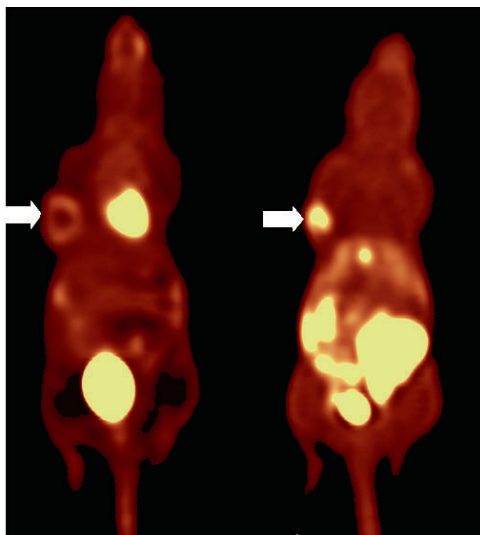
An example of an FDG PET scan showing a tumor with the highest uptake in the rim and an FMISO PET showing uptake in the center of the tumor.
